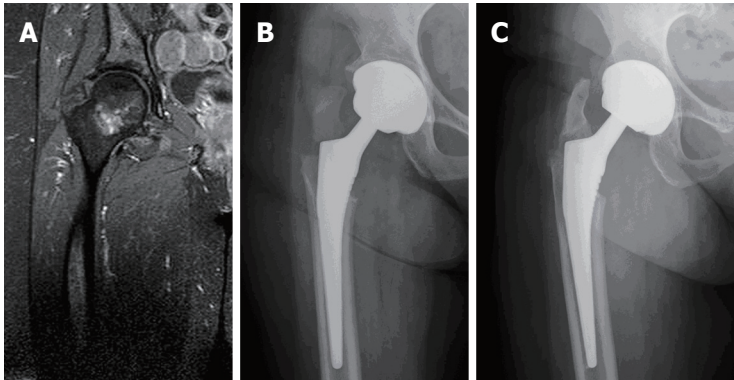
Radiographs of patient 3. A: Preoperative magnetic resonance imaging of a 64-year-old woman shows a high signal lesion confined to femoral head and neck; B: Postoperative radiograph at 6 wk after total hip arthroplasty with extensive excision at the intertrochanteric level shows an avulsion fracture of greater trochanter; C: Postoperative radiograph at 5 years after total hip arthroplasty with extensive excision at the intertrochanteric level shows no evidence of local recurrence and implant loosening or osteolysis.
